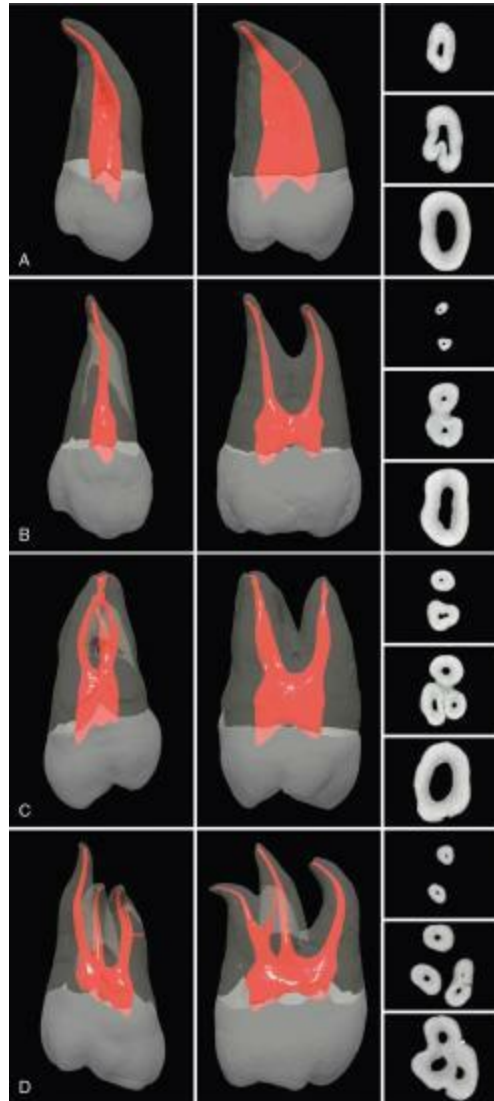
μ CT scans of maxillary third molars show a range of anatomic variations. A, Single-canal tooth. B, Two-rooted third molar. C, Two-rooted, three-canal third molar with significant root curvatures. D, Three-rooted, four-canal third molar. All teeth are shown from both a buccal (vestibular) and a proximal perspective, along with the cross-sectional anatomy at the coronal, middle, and apical levels. (See Video 7.11 online at the Expert Consult site for rotational views of these teeth.)
